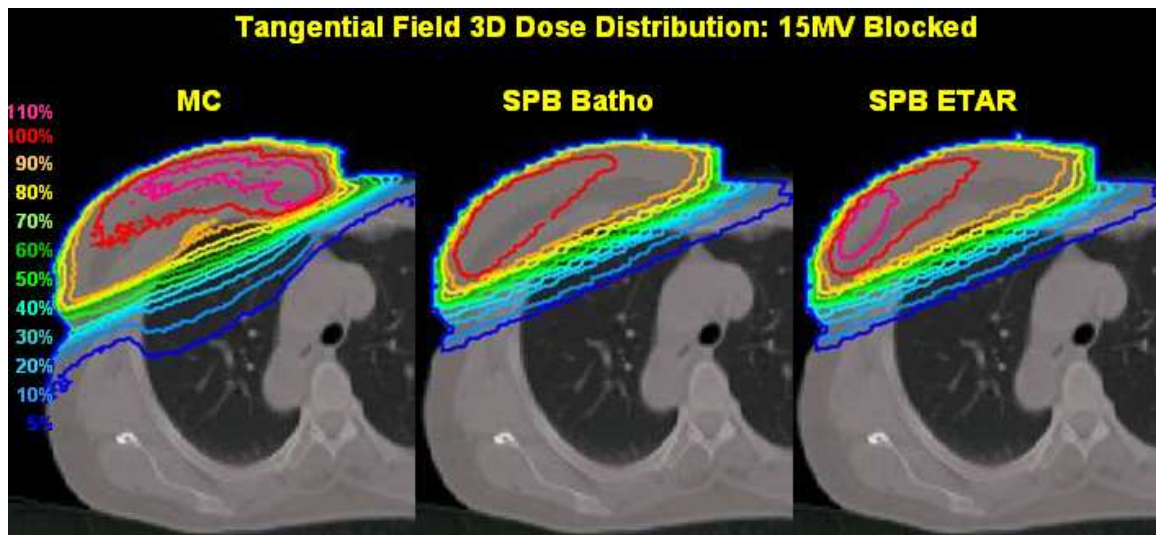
Comparison of the dose distributions from both blocked opposing tangential fields for the 15 MV breast case. Dose volume histograms were calculated from this data. The ICRU reference point was situated on a different CT slice.
